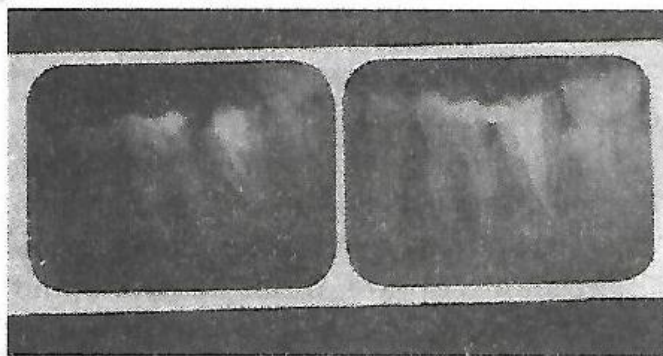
Case Report 1 (A. Pre-operative radiograph and B. Post-operative radiograph).
